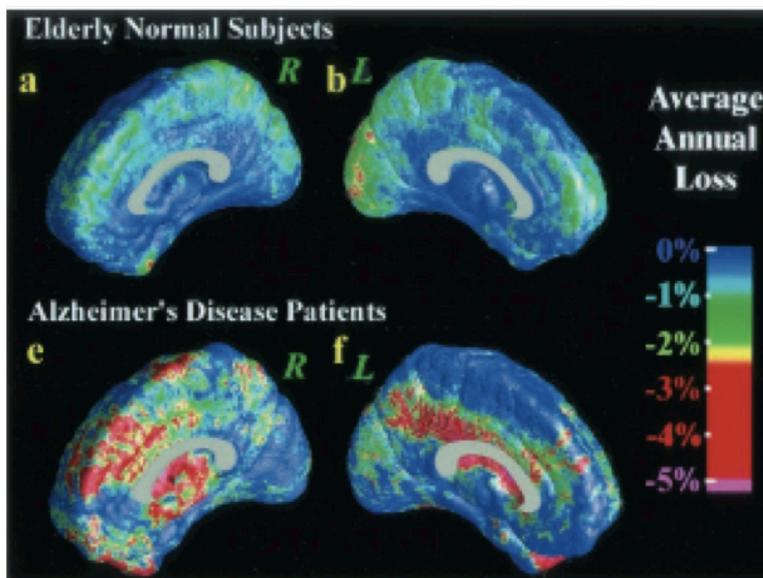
MRI image of AD patients (e, f) compared to normal elderly subjects (a,b). Depicted is the average annual gray matter loss in the right (R) and left (L) hemisphere. In AD patients, the gray matter loss spreads from the temporal to the frontal lobes and is more pronounced in the right hemisphere. Thompson *et al* 2003.
